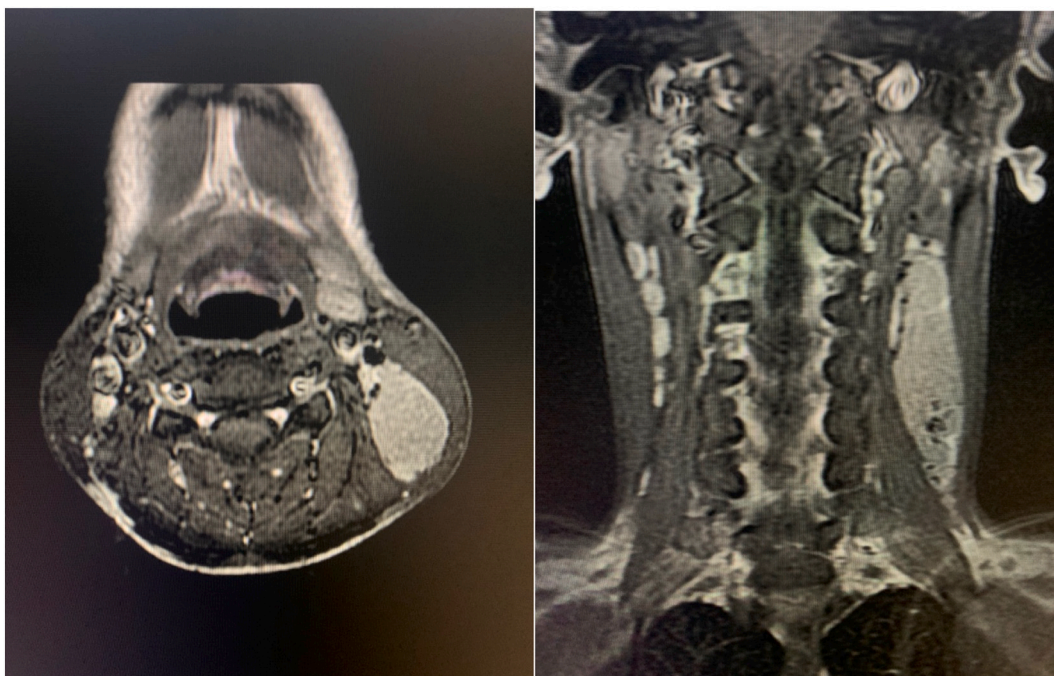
T1 MRI after contrast injection demonstrates a hyper-intense mass with multiple flow voids resembling salt and pepper appearance.
